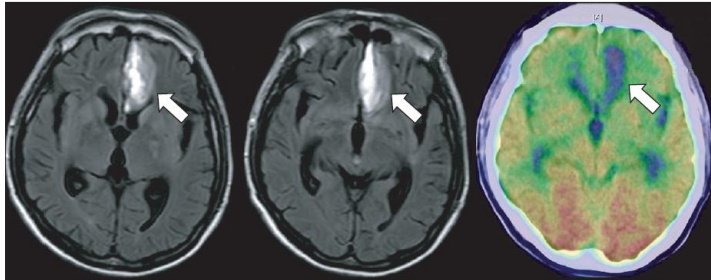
Magnetic resonance imaging of the brain from case 1, showing subacute intracranial hemorrhage in the left basal frontal lobe (arrows). Positron emission tomography also shows metabolic defects in the left basal frontal lobe along with diffuse hypometabolism in the bilateral frontal, temporal, and parietal cortex.
